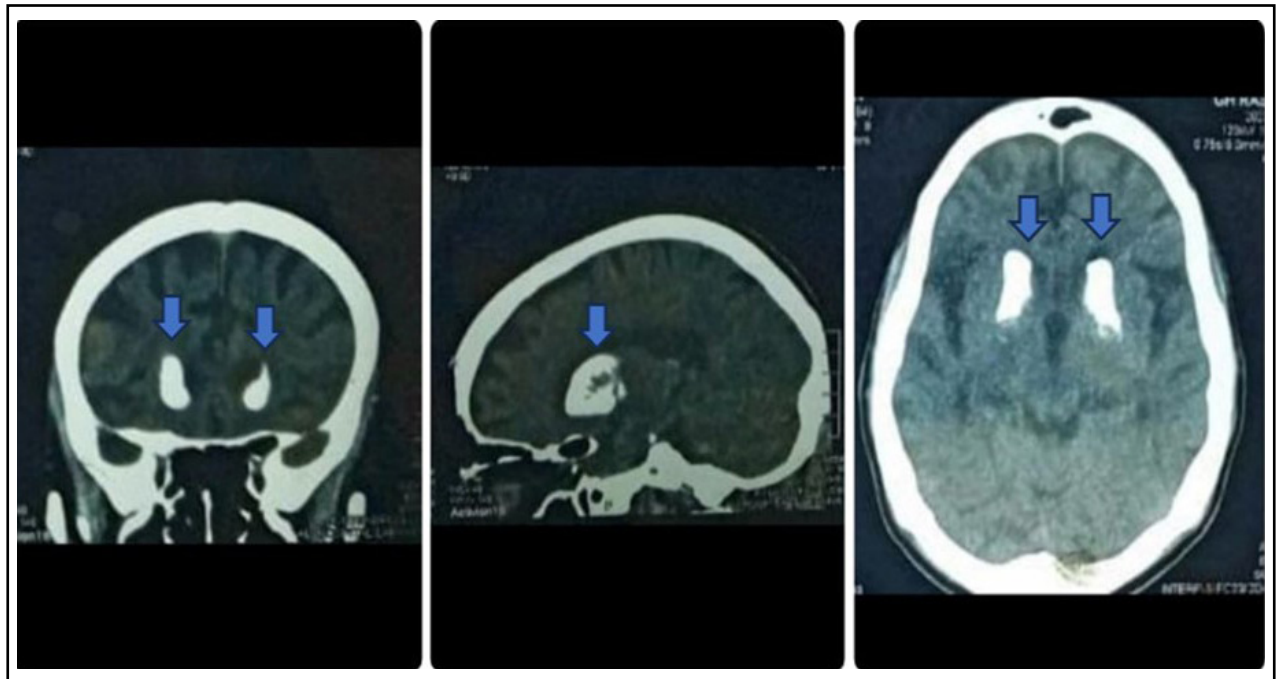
CT brain plain shows calcifications in basal ganglia that are bilaterally symmetrical as shown by blue arrows.
